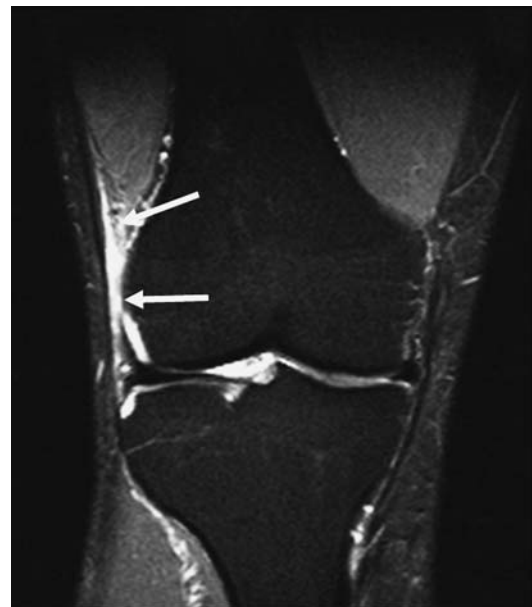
Iliotibial band syndrome. Coronal proton density fat suppressed MRI showing high signal deep to the iliotibial band (*arrows*)
